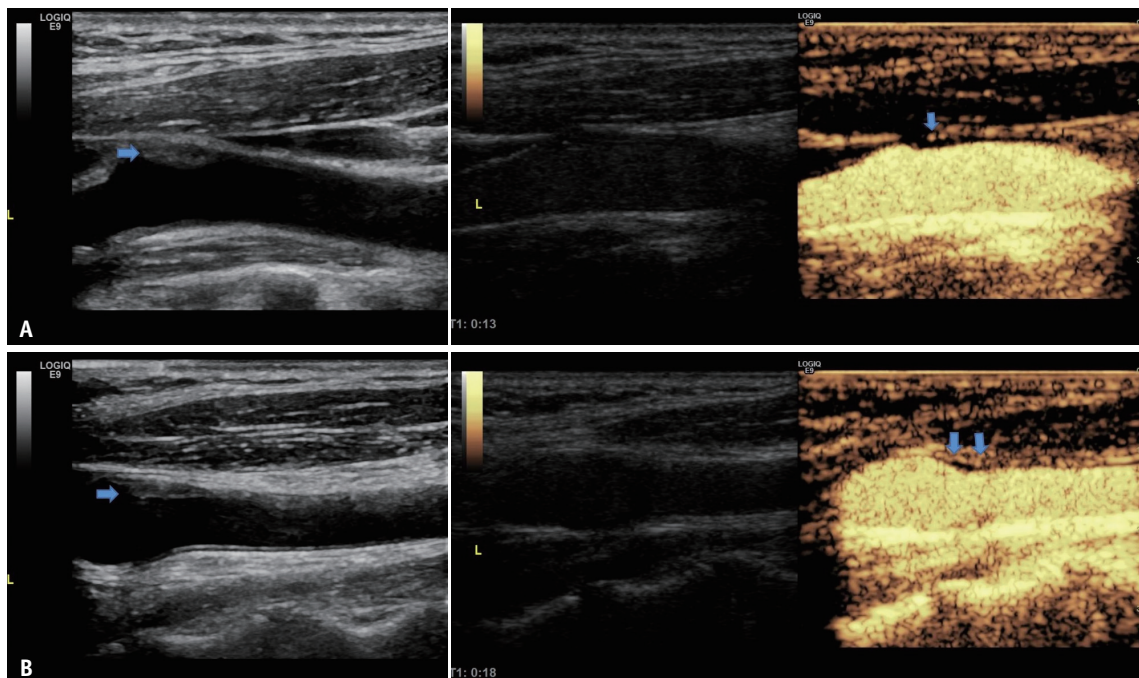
Typical examples of conventional longitudinal carotid ultrasonographic images (left panel) and grades of carotid intraplaque neovascularization, based on contrast-enhanced ultrasonography examination (right panel). A. Grade 1: absence of enhancement in the core of plaque, and enhancement limited to the adventitia side of the plaque (arrows). B. Grade 2: extensive contrast enhancement throughout the plaque (arrows).
